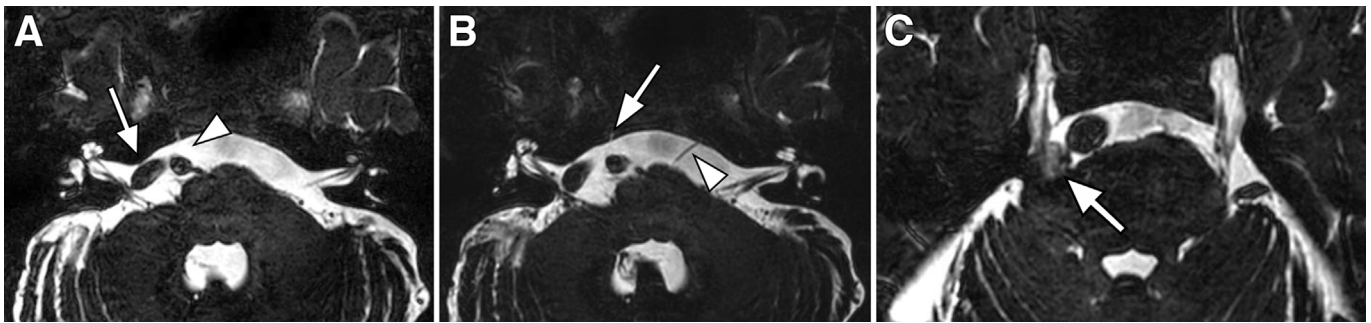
MRI performed six months after onset of right sixth nerve palsy, axial constructive interference in steady state (CISS) sequence. A. At the pontomedullary junction, dolichoectatic right vertebral artery courses rightward into the right cerebellopontine angle, adjacent to the seventh and eighth cranial nerves (arrow); the right sixth cranial nerve is not seen (arrowhead). B. Axial level slightly rostral to A. There is more high signal in Dorello's canal on the right side than on the left side (arrow), suggesting atrophy of the right sixth cranial nerve. The left sixth cranial nerve is visible (arrowhead). C. Axial level rostral to B. Decompression pad used 6 years earlier to treat right trigeminal neuralgia is visible adjacent to cisternal trigeminal nerve (arrow).
